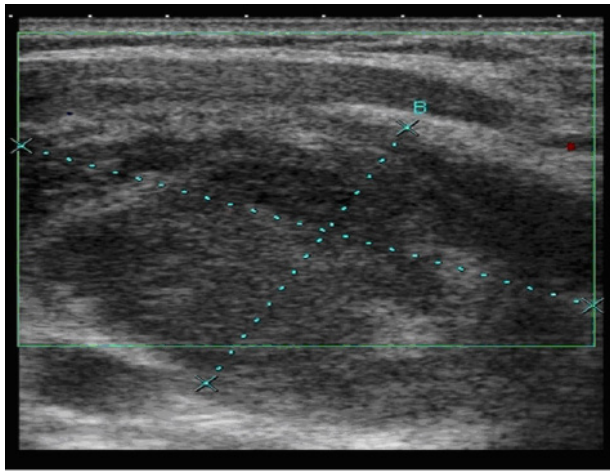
The thyroid ultrasound demonstrated a mixed-echogenic lesion at the right thyroid lobe with ill-defined margin, compatible with thyroid abscess with outward extension.
